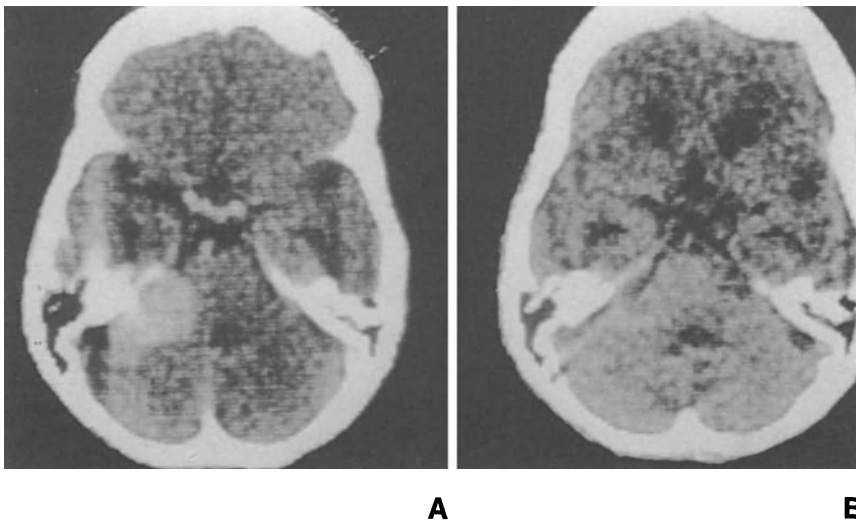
Acoustic neuroma. CT scans obtained before (A) and 2 years after (B) radiosurgery with Gamma Knife
